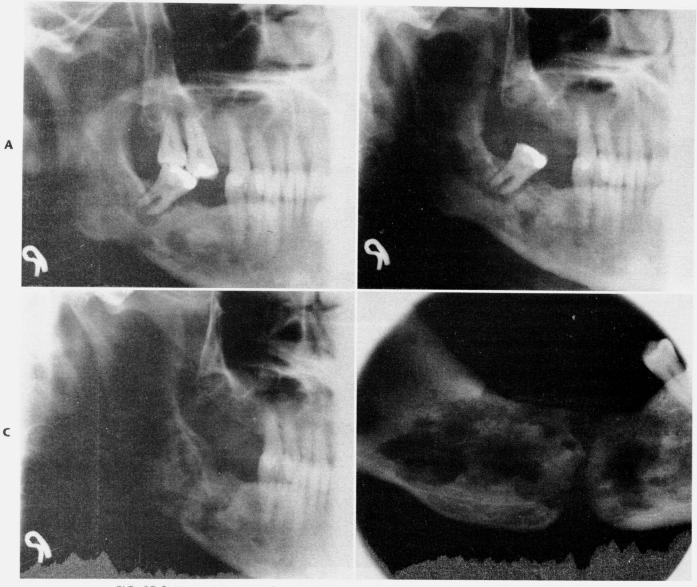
Progressive course of osteoradionecrosis. A, Radiograph showing radiolucencies in right mandible and around apex of molar tooth. B, Six months later, during which time antibiotics and local irrigations were used, radiolucent process is spreading into ramus. Molar was removed at this time. C, Five months after tooth removal, extraction site did not heal and destructive process spread, resulting in pathologic fracture of mandible. D, Radiograph after removal of devitalized bone, showing extent of process. (*Courtesy Dr. Richard Scoot, Ann Arbor, Ml.*)
